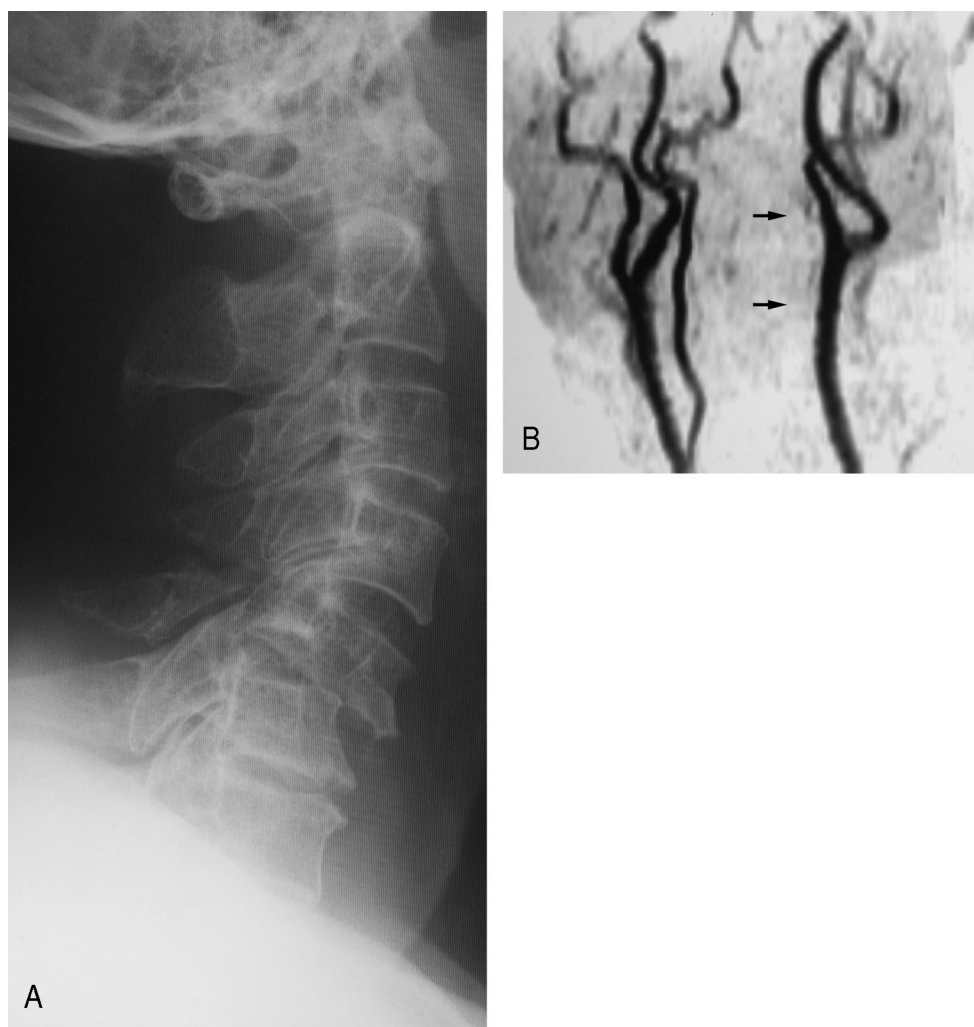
A, Lateral radiograph of a 55-year-old man (patient No. 6) who had destructive flexion injury of C5–C6 with unilateral facet dislocation. B, MRA obtained 6 hours after injury shows complete occlusion of the left vertebral artery (arrows).
